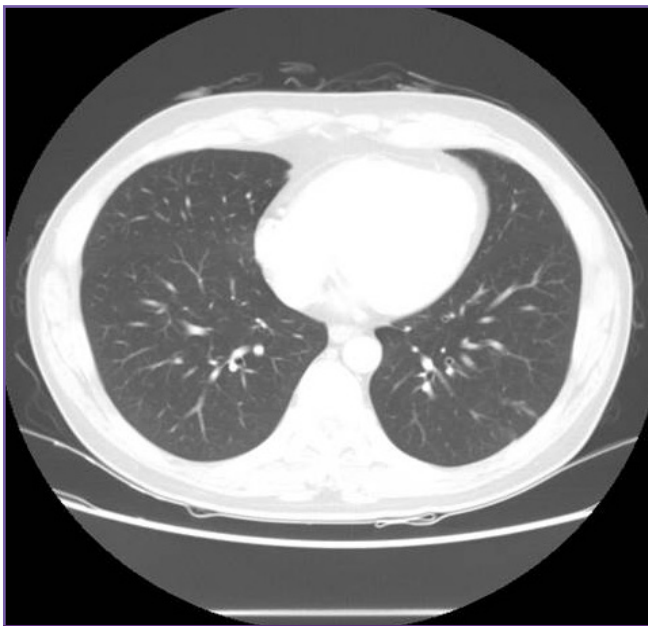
4-month follow-up chest CT shows a marked decrease in the size of the nodule in the left lower lobe.
